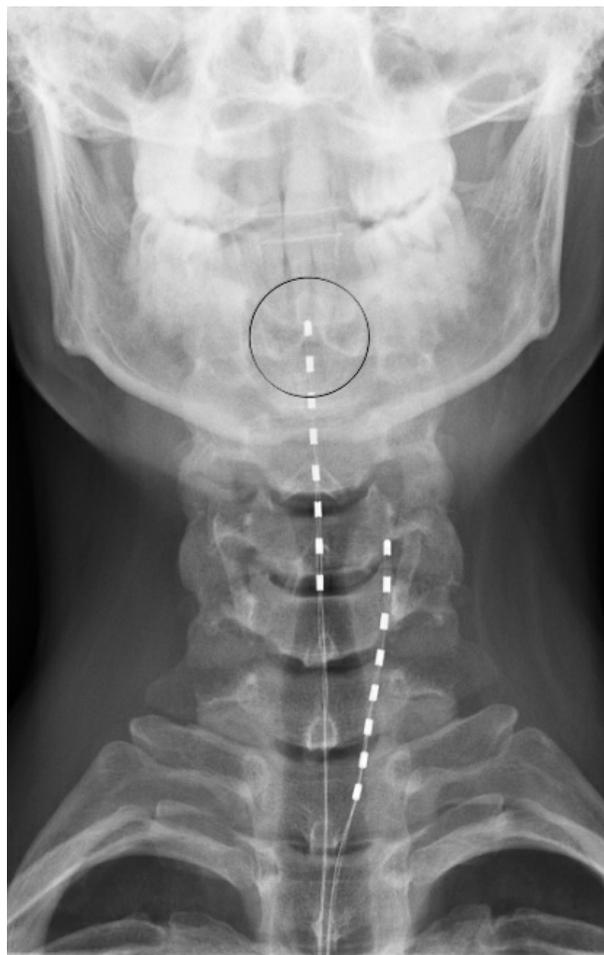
AP radiograph of the lead position with implantation of the second lead medially up to C2.
